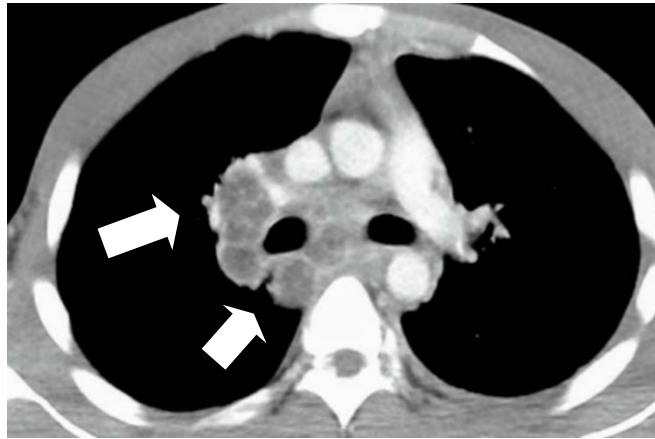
Chest computed tomography scan – numerous enlarged and necrotic lymph nodes in the mediastinum.
